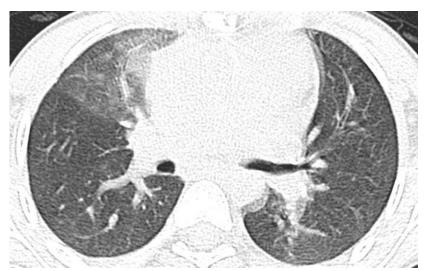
Thoracic CT scan with a parenchymal window showing areas of ground-glass opacities on medial segment of the middle lobe, indicating alveolar hemorrhage
